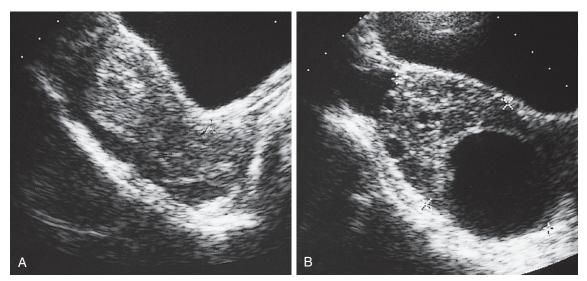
Ultrasound findings in the diagnosis of pelvic or abdominal pain. A, This image shows an abnormal amount of fluid in the cul-de-sac released from a ruptured ovarian cyst in a 15-year-old with left-lower-quadrant and midline pelvic pain. B, In a 12-year-old girl with a 4-day history of colicky right-lower-quadrant pain, ultrasound demonstrates a single large abnormal cyst and multiple small physiologic cysts. Operative diagnosis was right ovarian torsion.
